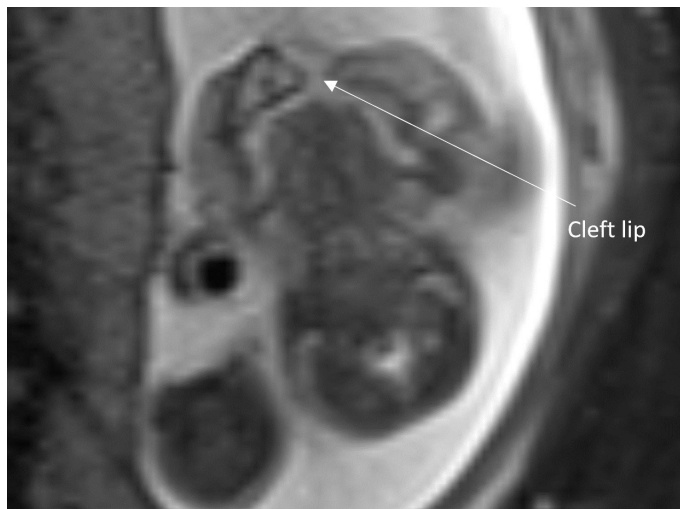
T2 Axial MRI image of cleft lip in 21 week fetus
